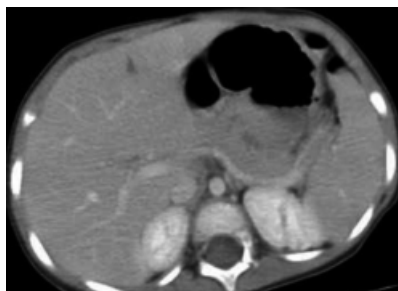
Axial plane of an abdomen CT scan. Adapted from [2]
